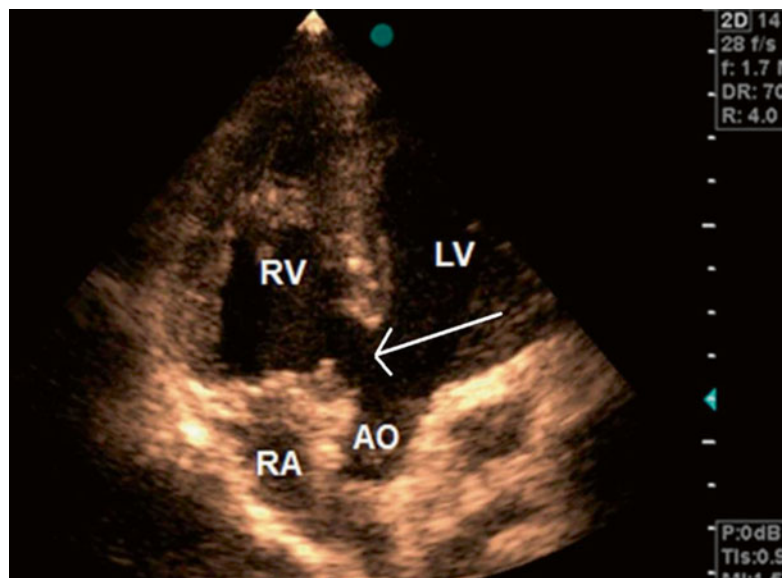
Transthoracic echocardiography in five-chamber view showing large perimembranous VSD (white arrow). RV right ventricle, LV left ventricle, RA right atrium, Ao aorta
